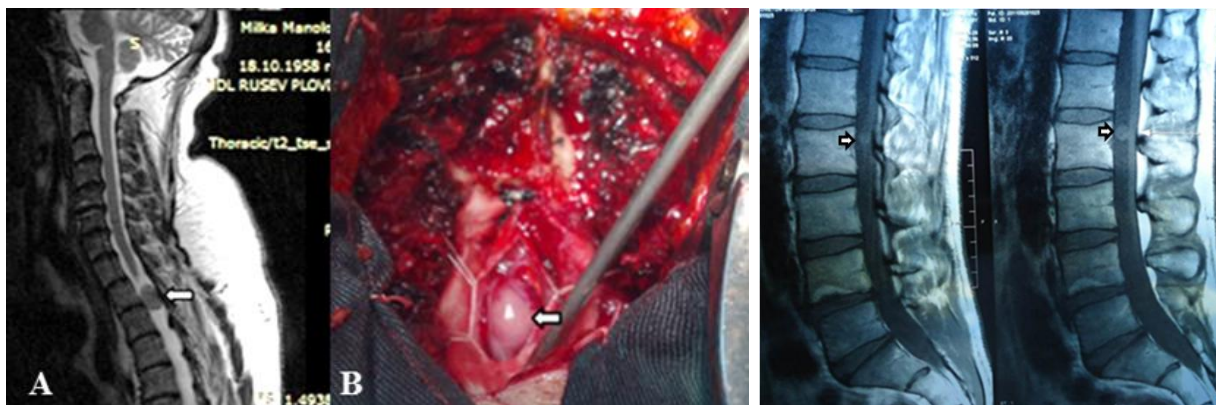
A/ MRI image of dorsolateral meningioma at level Th₂₋₃ ;
